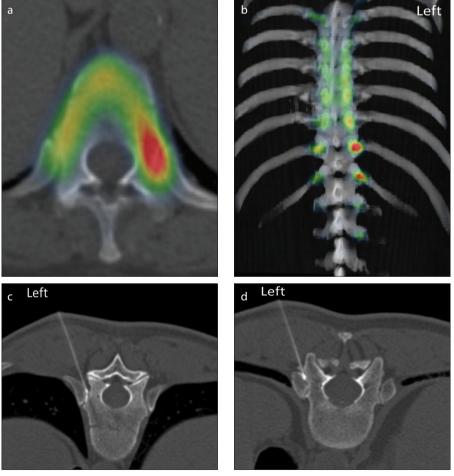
a–d. SPECT-CT images of a 76-year-old woman (case 2) with left lower thoracic back pain and increased ^{99m}Tc MDP activity. Panel (a) shows increased bone tracer activity at the left 11th and 12th (not shown) costovertebral joints. Posterior volume-rendered reformatted image (b) shows increased activity relative to the adjacent costovertebral joints. An alternative pain generator was present at the left L2 facet (not shown). The left 11th (c) and 12th (d) costovertebral joints were each injected with 3 mg of betamethasone and local anesthetic. The patient had no pain relief after injection.
